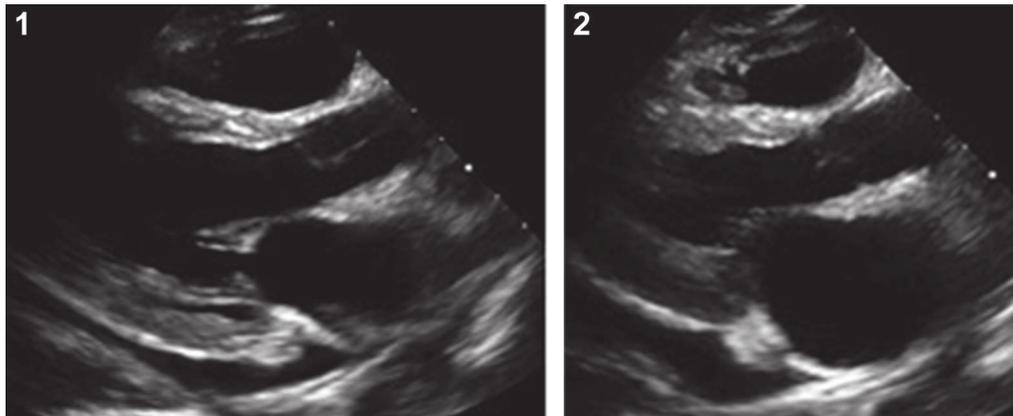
Transthoracic echocardiography. (1) Parasternal view in diastole: pericardial effusion. (2) Parasternal view in systole: akinesis of the basal anteroseptal segment.
